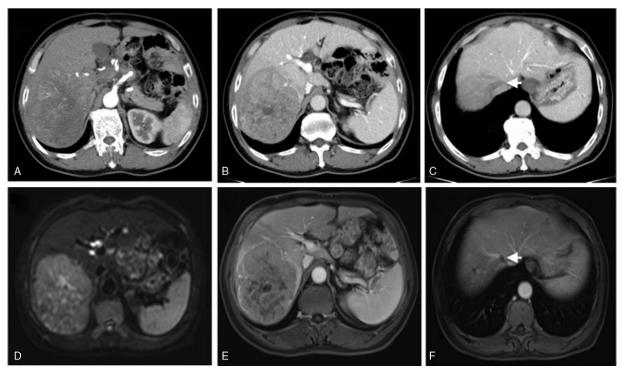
CT and MRI revealed parenchymal occupying lesion (15 × 10 cm) in the right lobe of liver, which could be explained by primary liver cancer (A and D); tumor thrombus was not detected in the portal vein (B and E), but was determined in right hepatic vein (C and F). CT = computed tomography, MRI = magnetic resonance imaging.
